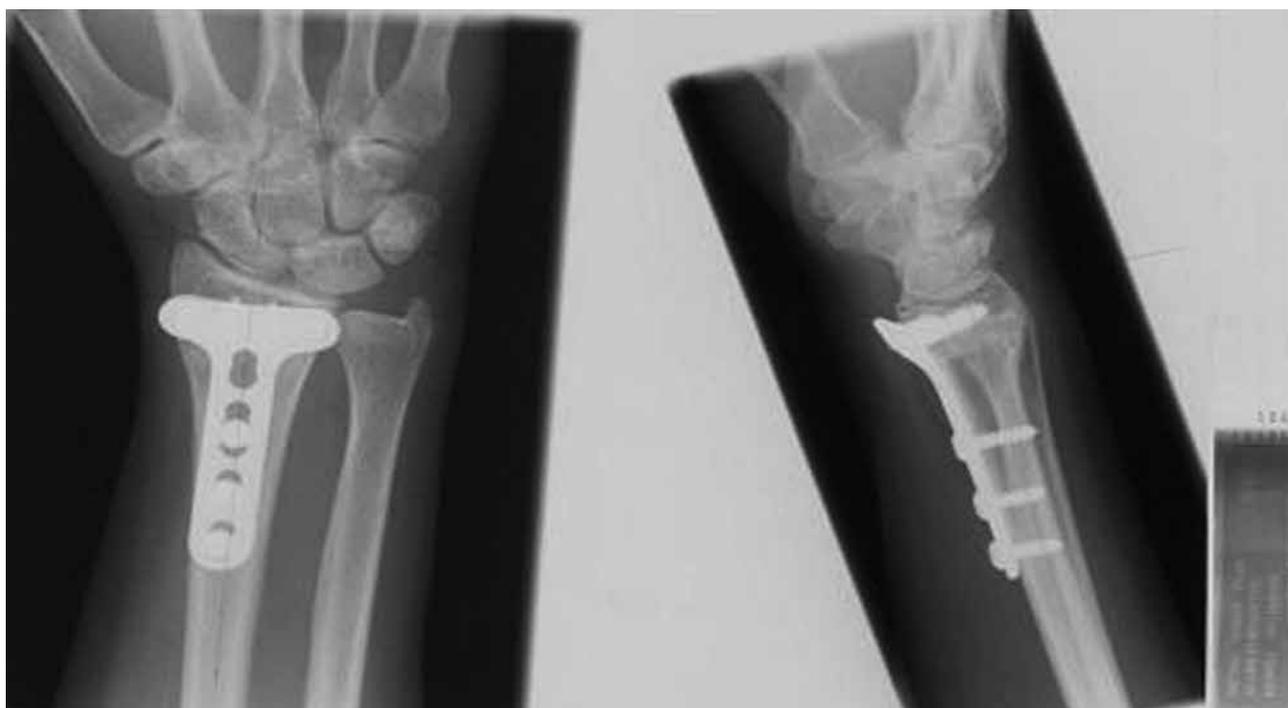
Anteroposterior (A) and (B) lateral radiography at 6 months
